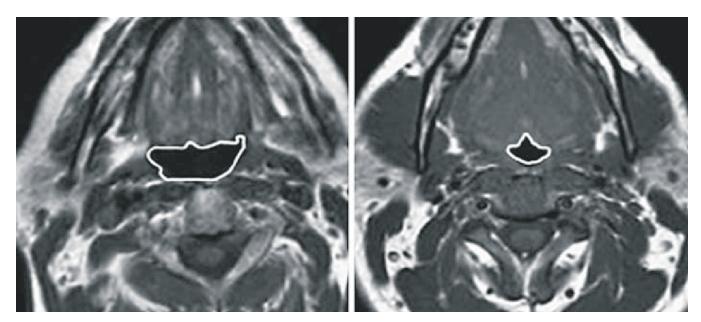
Axial T1-weighted spin-echo images of the pharynx at the retroglossal level in an obese control (left) and a patient with OSA (right): note the increase in the anterior-posterior diameter with evidence of lateral narrowing (reduction of transversal diameter of pharynx air column) in patient with OSA. [Source : Ref. 32. Reprinted with permission].
